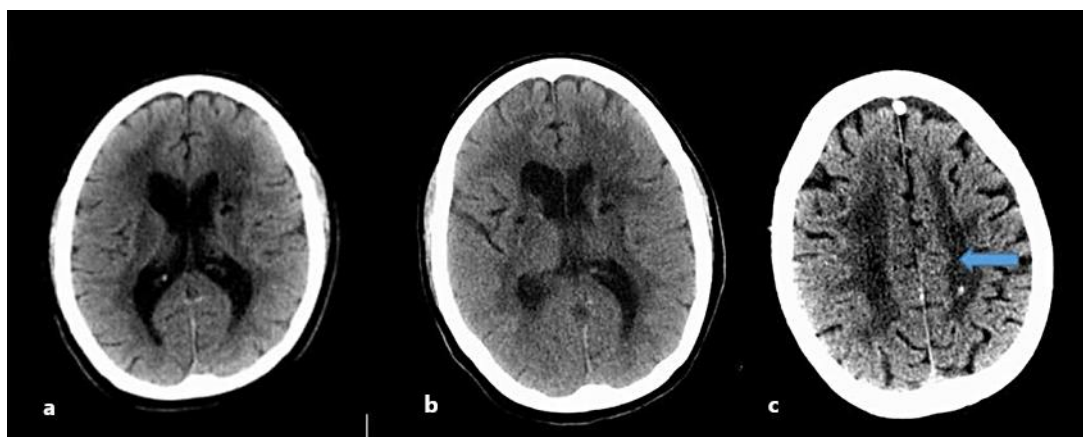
An initial head CT made at an outside facility and at our institution shows a middle-aged woman presenting with confusion and weakness. a Initial outside facility head CT. b, c Initial head CT performed at our institution. Confluent hypoattenuation of the cerebral white matter with superimposed focal hypodensities involving the basal ganglia. A small punctate hyperdensity was a concern for hemorrhage (arrow).
